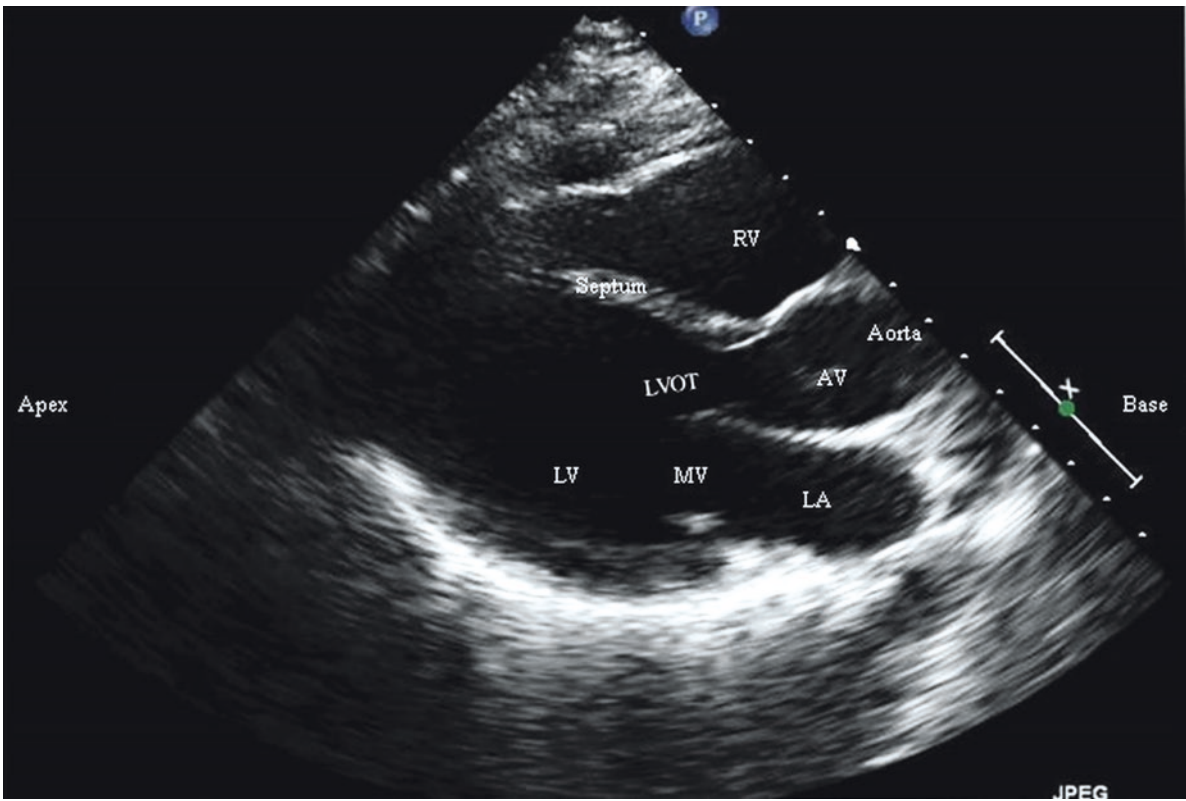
Parasternal long-axis view shown at the end of diastole
